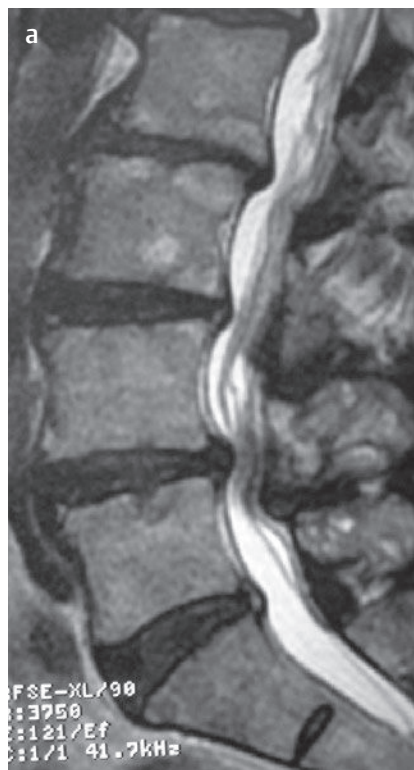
Lumbar stenosis. (a) A sagittal T2-weighted image shows multilevel stenosis in the lumbar spine. (b) An axial T2-weighted image at the L4-L5 level shows moderate-severe stenosis secondary to contributions from a central disc bulge (arrow), ligamentum flavum hypertrophy (arrowheads), and facet arthropathy (asterisks).[†]
